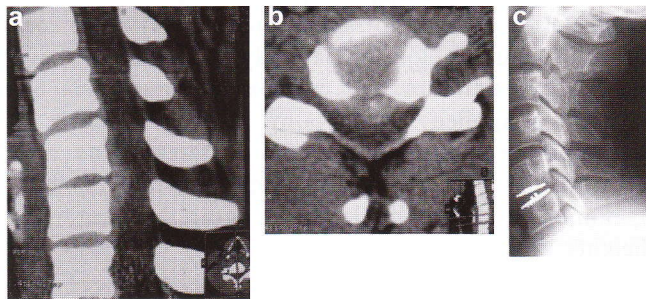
Ideal indication for the Mobi-C® disc replacement: soft medial herniated C5-C6 disc. a: sagittal CT scanner slice; b: axial CT scanner slice; c: postoperative lateral film
